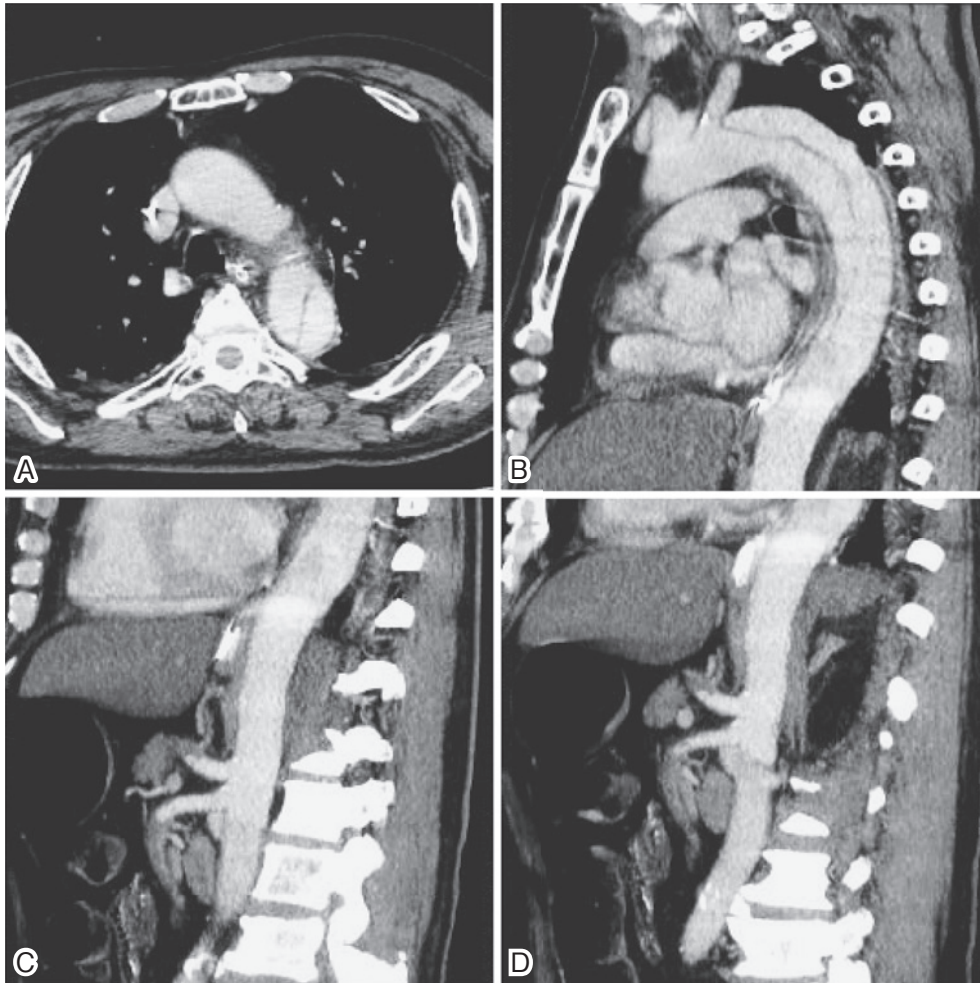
Follow-up contrast-enhanced CT demonstrates acute aortic dissection from the distal arch to the infrarenal abdominal aorta, with no evidence of aortic rupture (arrows indicating the dissection and false lumen). CT also shows: 1) the celiac and superior mesenteric arteries being supplied from the false lumen, with thrombotic obstruction within several centimeters from their origins (arrowheads), and 2) marked compression of the true lumen by the false lumen due to dissection.
